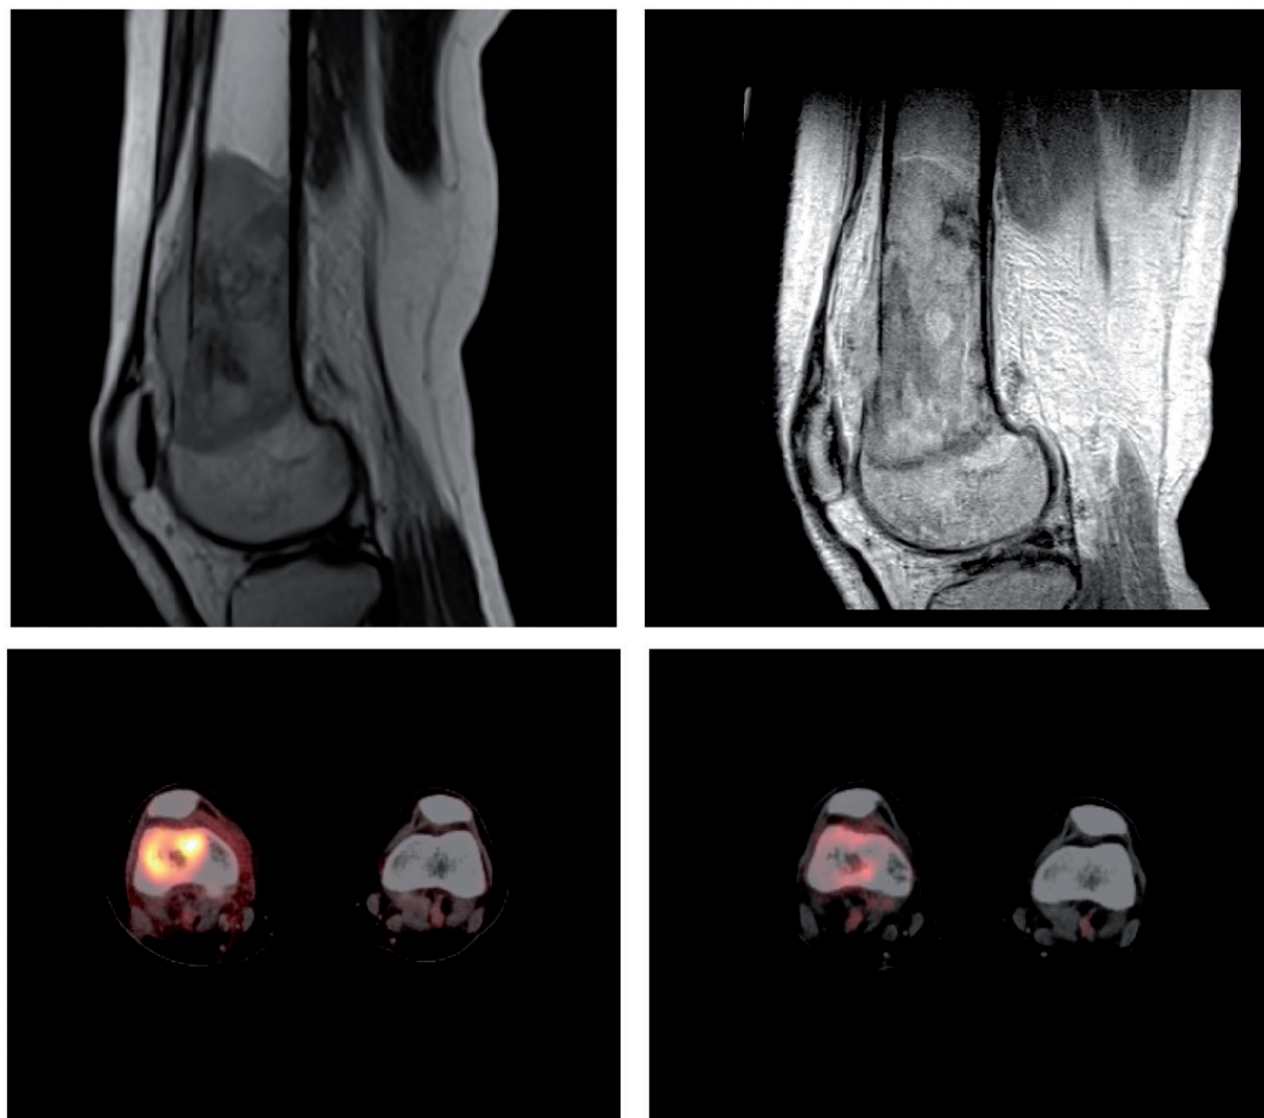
MRI and PET scan showing the tumor before treatment (left) and after two courses of chemotherapy (right).
